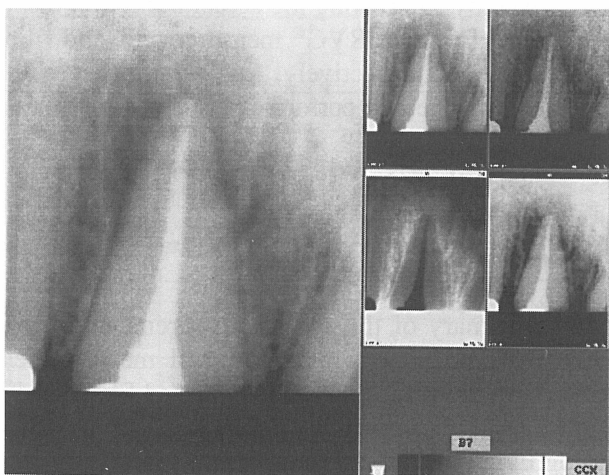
RVG® 32000 thermal print image of tooth with associated periapical radiolucency. Dimensions of the lesions were estimated using direct measurements made from the small images to the left of the print
